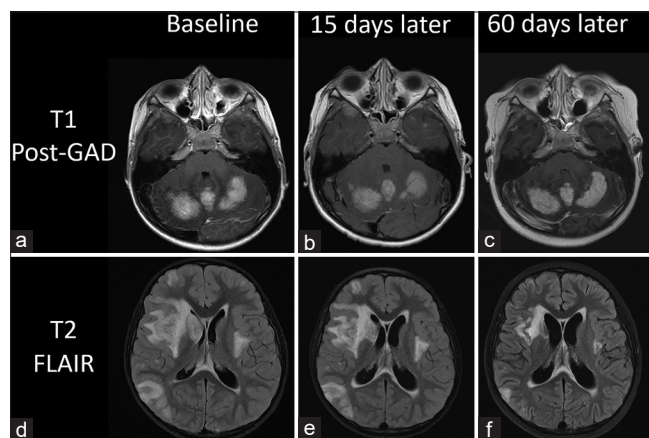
Longitudinal changes on brain MRI at 15 and 60 days since diagnosis. (a-c) reveal post-GAD enhancement in the cerebellum, demonstrating persistent and worsening edema at 60 days. (d-f) show T2-FLAIR lesions evolution over time. Right frontal hemisphere lesion is improved (f) when compared to baseline (d). However, there is increase periventricular signal as well as the size of the ventricles concerning for development of noncommunicating hydrocephalus which is consistent with the worsening inflammation of the cerebellum inflammation. Although not displayed in the figure, there is mild infratentorial herniation of the cerebellar tonsils through the foramen magnum. FLAIR: fluid-attenuated inversion recovery; GAD: gadolinium
